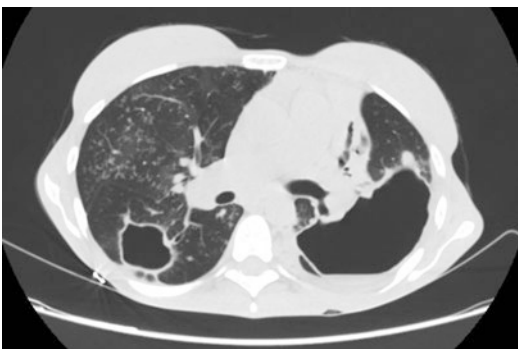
Chest computed tomography in an HIV-positive patient with paradoxical TB IRIS
